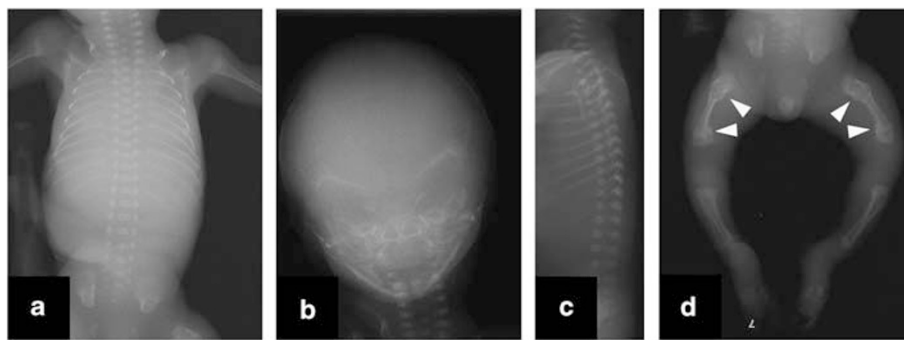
Radiographs of II:2 from family 3. (a) Slender ribs. No rib fractures, two fractures of right femur with callus formation. (b) Underexposed radiograph, which makes evaluation for mineralization difficult. The calvaria seem to be thin for gestational age. (c) No vertebral abnormalities. (d) Two fractures of both femora with callus formation (arrowheads).
